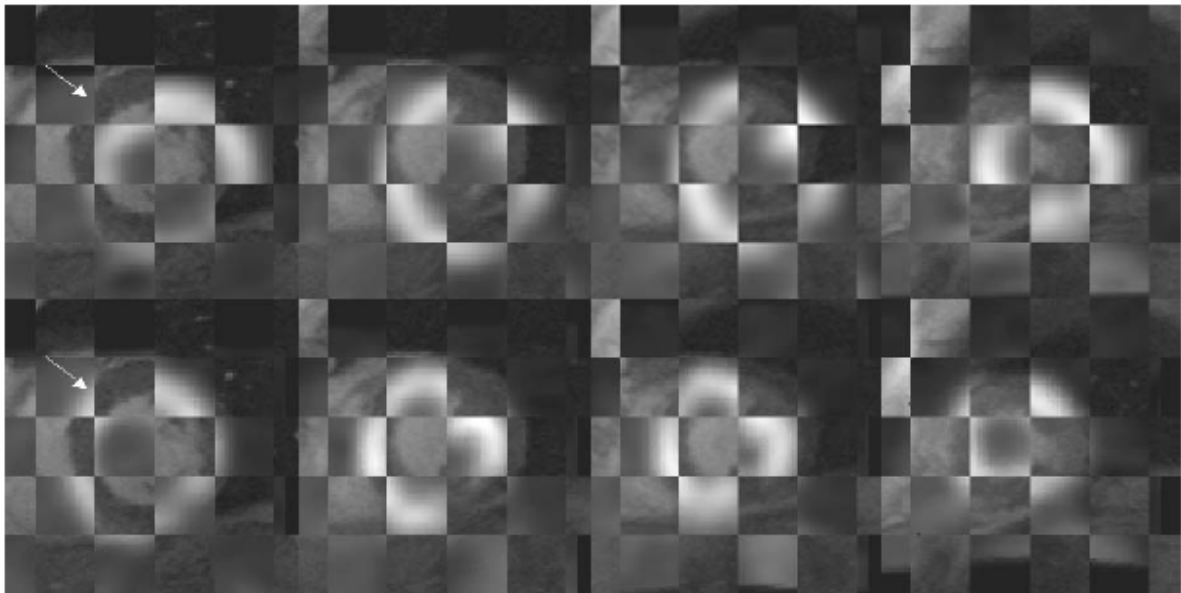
Recalage élastique d'images cardiaques TEP-FDG d'émission et IRM en petit axe pour le patient E3. Pour quatre niveaux de coupe, (haut) Recalage rigide, (bas) Recalage élastique.*
